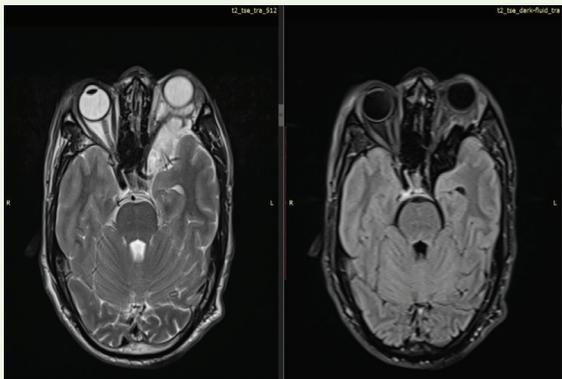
MRI brain, axial T2-weighted image OF 39-YEAR-OLD GENTLEMAN WITH KNOWN NF-1 demonstrates prominent arachnoid spaces in the left anterior temporal region, secondary to the orbital encephalocele. There is compression and medial deviation of the left optic nerve without abnormal enhancement, excluding optic nerve glioma or optic nerve sheath meningioma. There is severe narrowing of left superior orbital fissure and compression of optic nerve at this level.
